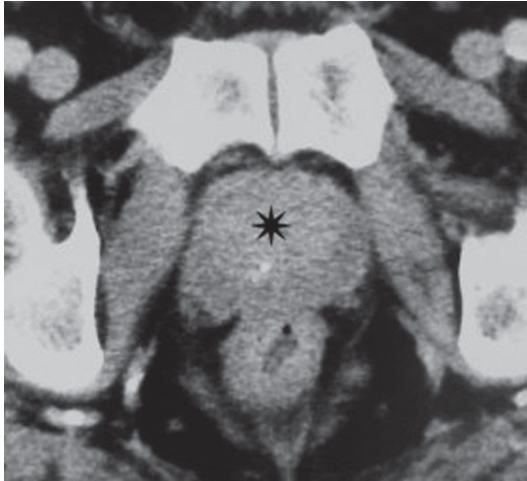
Computed tomography. Prostatic adenoma. The lesion (*asterisk*) is recognizable due to the increased hyperattenuation with respect to the peripheral zone
